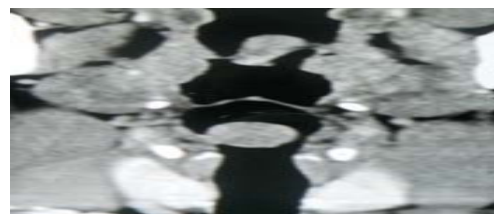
CT image coronal section showing mass arising from posterior pharyngeal wall
